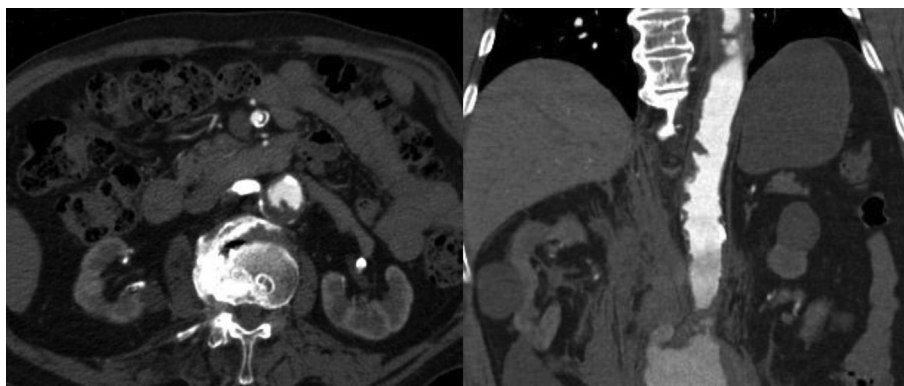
Features of a shaggy aorta on contrast enhanced computed tomography.
